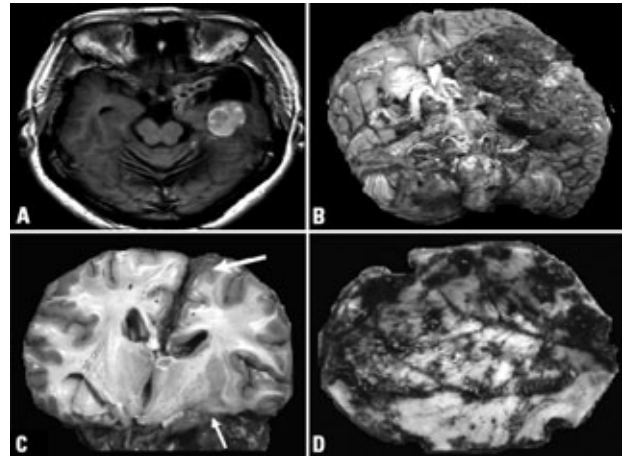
[A] The MRI-imaging showed a lesion signal intensity on T2-weighted images varies after contrast enhancement. [B] Brain gross aspect. [C] The tumor was an irregular tan-gray mass of 4×4 cm, on the temporal and parietal right lobes. On a surface cut, focal areas of glistening grayish-white substance were admixed with poorly demarcated firm areas, necrosis and hemorrhage and in [D] showed dissemination along skull base.
